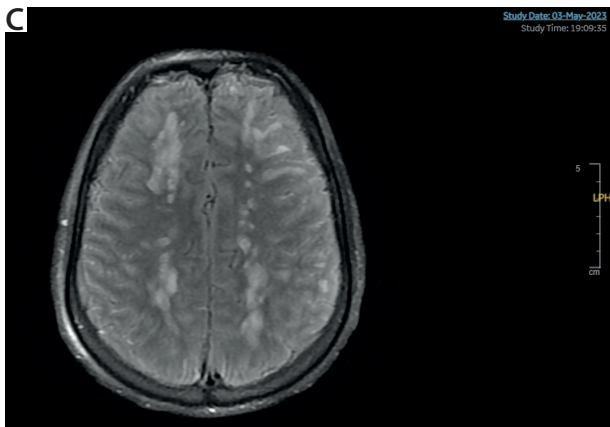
Magnetic resonance imaging on 16th day of hospitalisation
